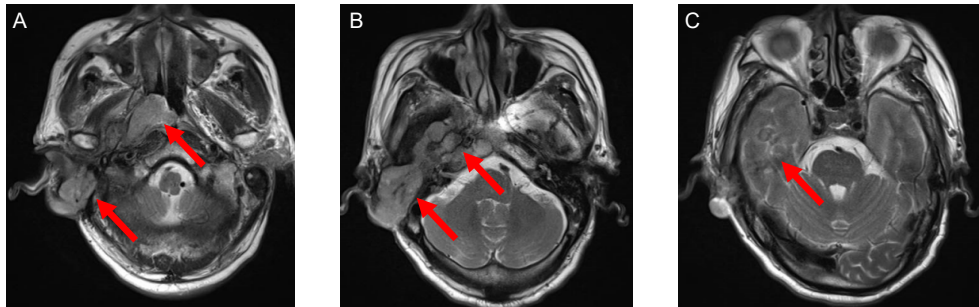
Magnetic resonance imaging before treatment (June 24, 2022).
